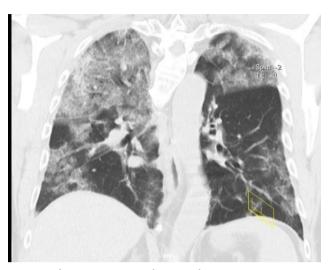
Chest HRCT coronal image demonstrating extensive ground glass opacities.
